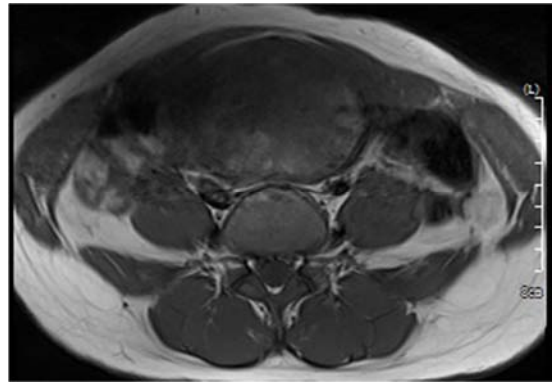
Placenta implantation type 1. A 30-year-old patient, irregular vaginal bleeding after miscarriage. MRI shows the residual placenta and it is close to the anterior wall of the uterus. The endometrial display is not clear in T2WI. A, T1WI was slightly low signal. B, T2WI shows the residual placenta was in mixed signal. C, CE-T1WI shows the residual placenta was low signal.
